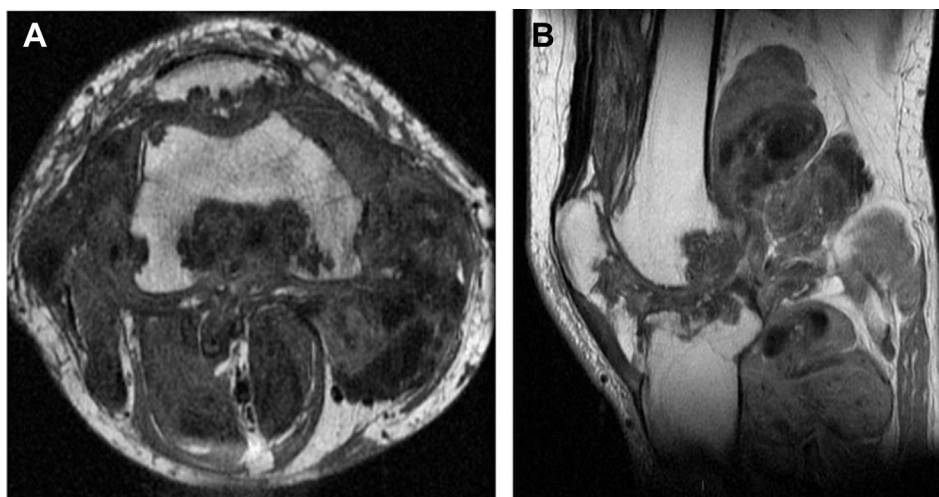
T1-weighted axial (A) and T2-weighted sagittal (B) MRI-scan showing extensive D-TGCT of the knee with a large extraarticular component and bone erosion. MRI, magnetic resonance imaging; D-TGCT, diffuse-type tenosynovial giant cell tumour.
